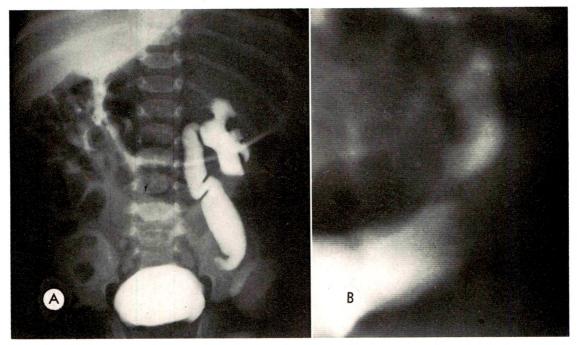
(A) Intravenous urogram at 1 month of age showing partial obstruction of the distal left ureter. (B) Fluoroscopic spot roentgenogram of the distal left ureter demonstrating a transverse filling defect above the ureterovesical junction.
